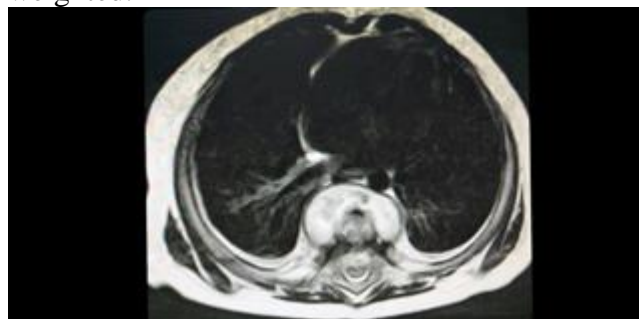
Axial view of MRI Spine at level of T7.
